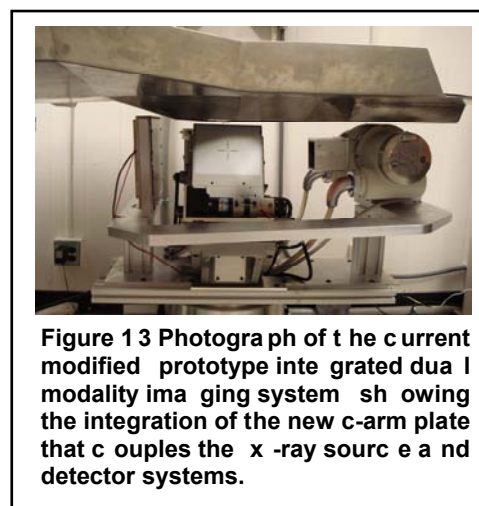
Photograph of the current modified prototype integrated dual modality imaging system showing the integration of the new c-arm plate that couples the x-ray source and detector systems.
